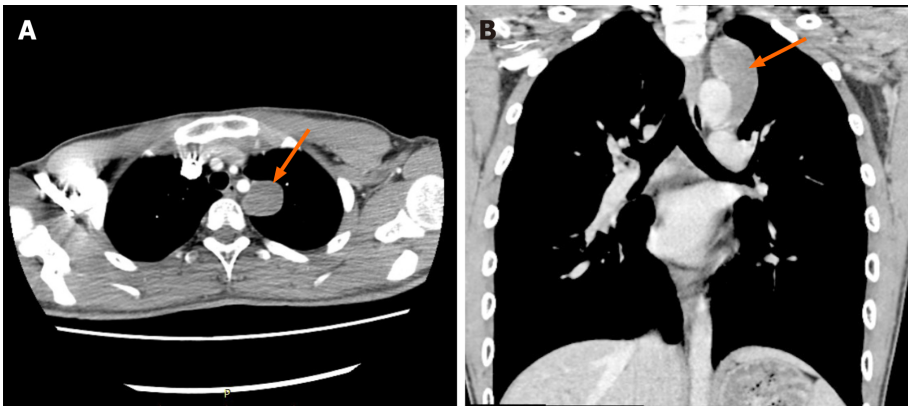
Chest computed tomography scan before surgery suggested a mediastinal mass above the left aortic arch. A: Cross-section of chest computed tomography (CT); B: Coronal section of chest CT. The orange arrows refer to the mediastinal mass.
